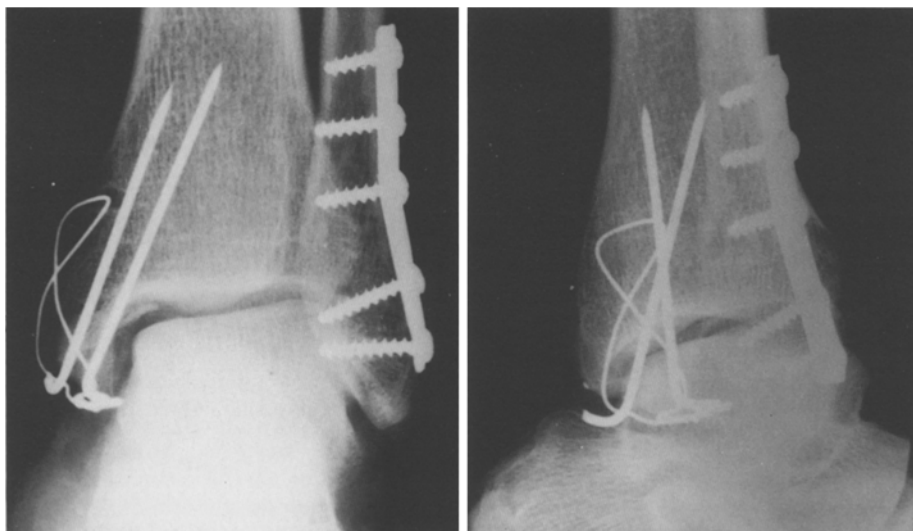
Post-operative X-ray photograph of the left ankle joint (1973)
